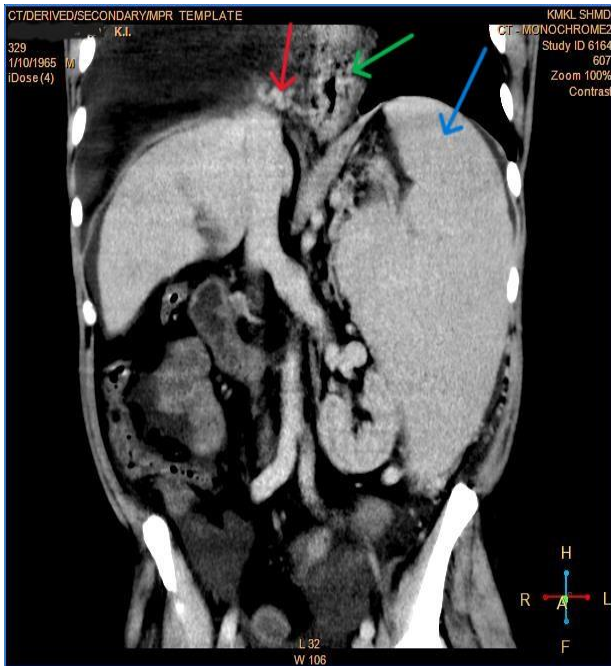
Axial computed tomography with contrast in the portal vein demonstrates: the presence of esophageal varices, which are visualized in the form of tortuous tubular structures with an uneven contour, protruding into the lumen of the esophagus (green arrow), v.diaphragmatica inferior (red arrow, draining blood from the esophageal varices into the v.cava inferior), splenomegaly (blue arrow)
